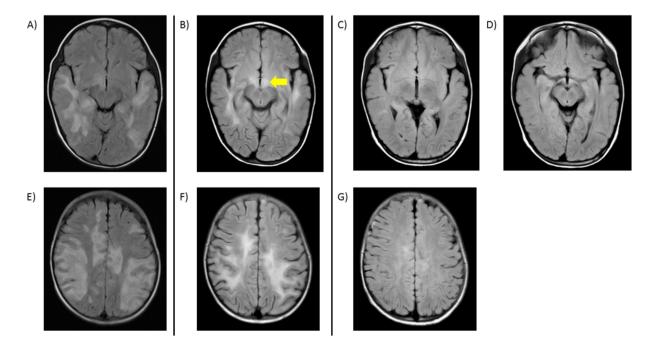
MRI findings (axial FLAIR imaging). (A and E) Evidence of extensive white matter lesions at the time of admission. (B and F) Decreases in initial lesion size concomitant with the occurrence of a novel lesion (arrow) 14 days after the first MRI. (C, D, and G) Follow-up studies revealed marked resolution of lesions 9 months after the first MRI.
